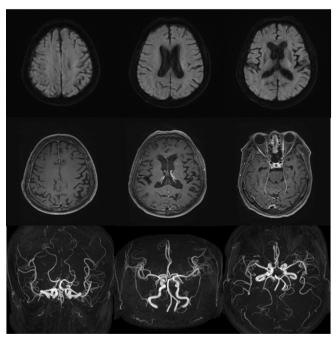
Normal brain magnetic resonance imaging and magnetic resonance angiography on the first day.
